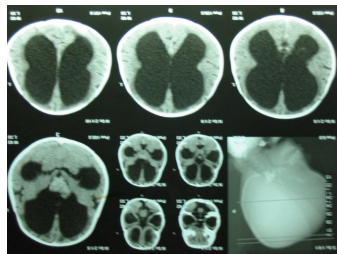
1 CT film showing hydrocephalus
